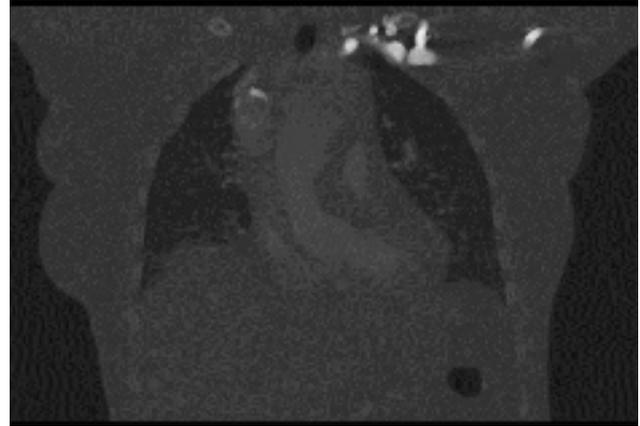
CT- angiography view
